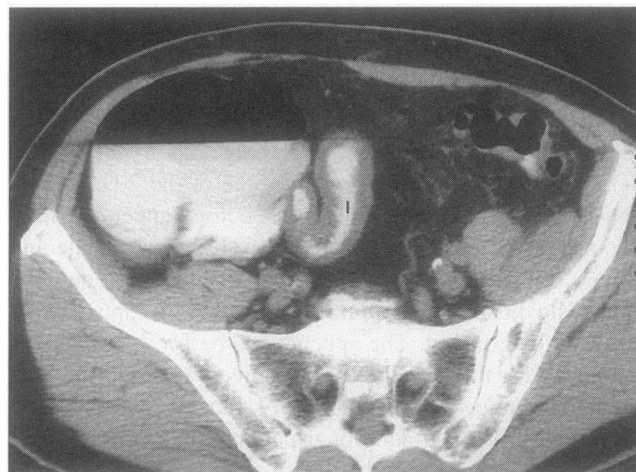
Axial CT scan of an 81-year-old man with a thickened terminal ileum (I), a finding consistent with infectious ileitis.
